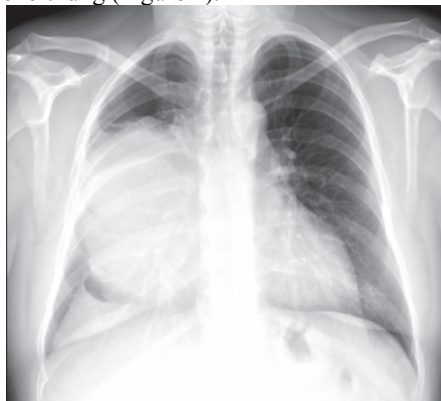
Chest X-ray finding at the admission: A massive, homogenous infiltration in the lower 2/3 of the right lung.
